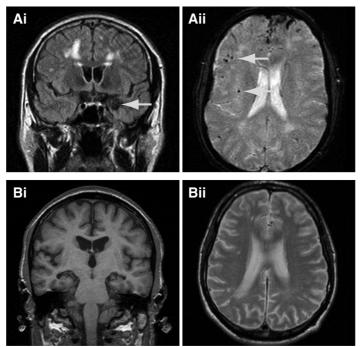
MRI scans from APPd patients. (A) proband 1 showing extensive white matter abnormalities (Aii) and an amygdala hemorrhage (Ai, arrow) (B) proband 2 (aged 47) showing white matter abnormalities on T2 weighted scans (Bii) and hippocampal atrophy (Bi).
